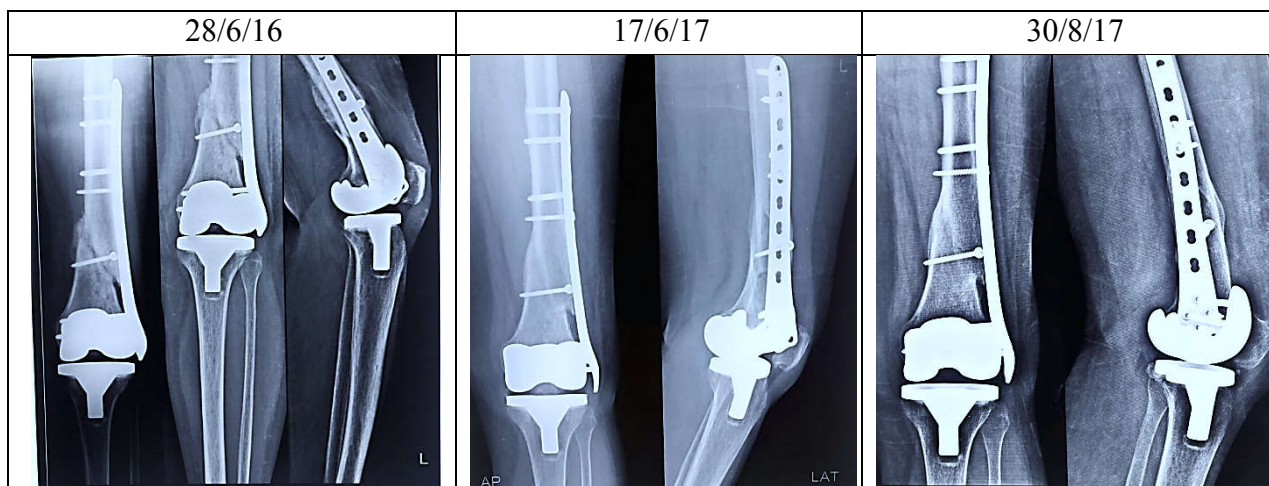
X-ray distal end of left femur antero-posterior & lateral view of case 5
